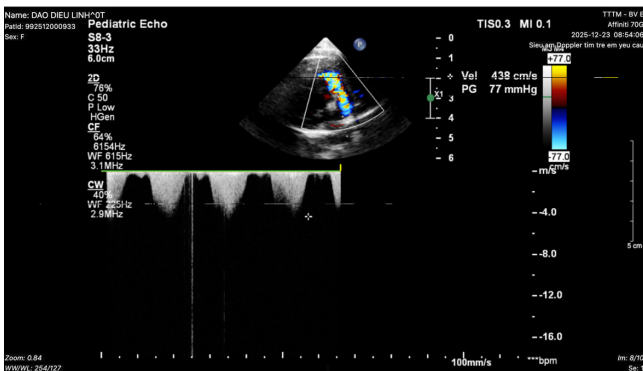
Preoperative Doppler echocardiography showing severe right ventricular outflow tract obstruction with a peak velocity of 4.38 m/s and a peak pressure gradient of 77 mmHg
